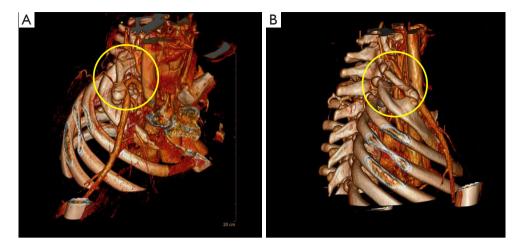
Computed tomography chest scan 3D reconstruction showing the presence of a cervical rib. (A) Sagittal view; (B) lateral view.
